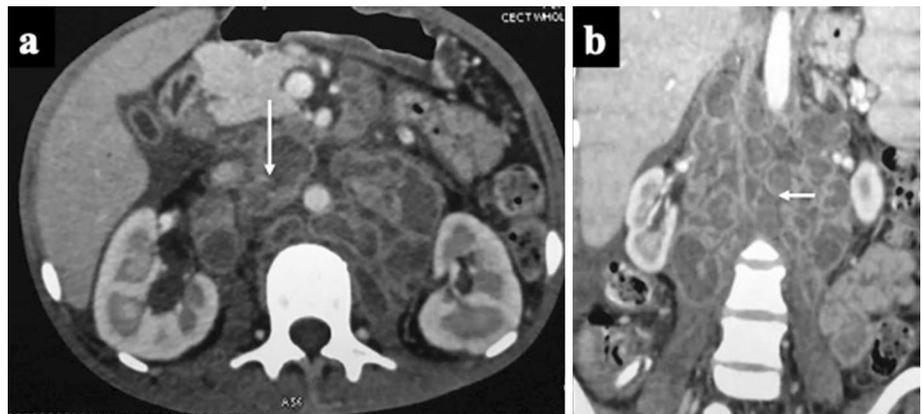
Tuberculosis in a 32-year-old female presenting with fever and weight loss. Axial (a) and coronal (b) contrast-enhanced CT images showing multiple conglomerate nodes in the mesenteric root with central necrosis and peripheral rim enhancement, suggestive of tuberculosis (white arrows)
